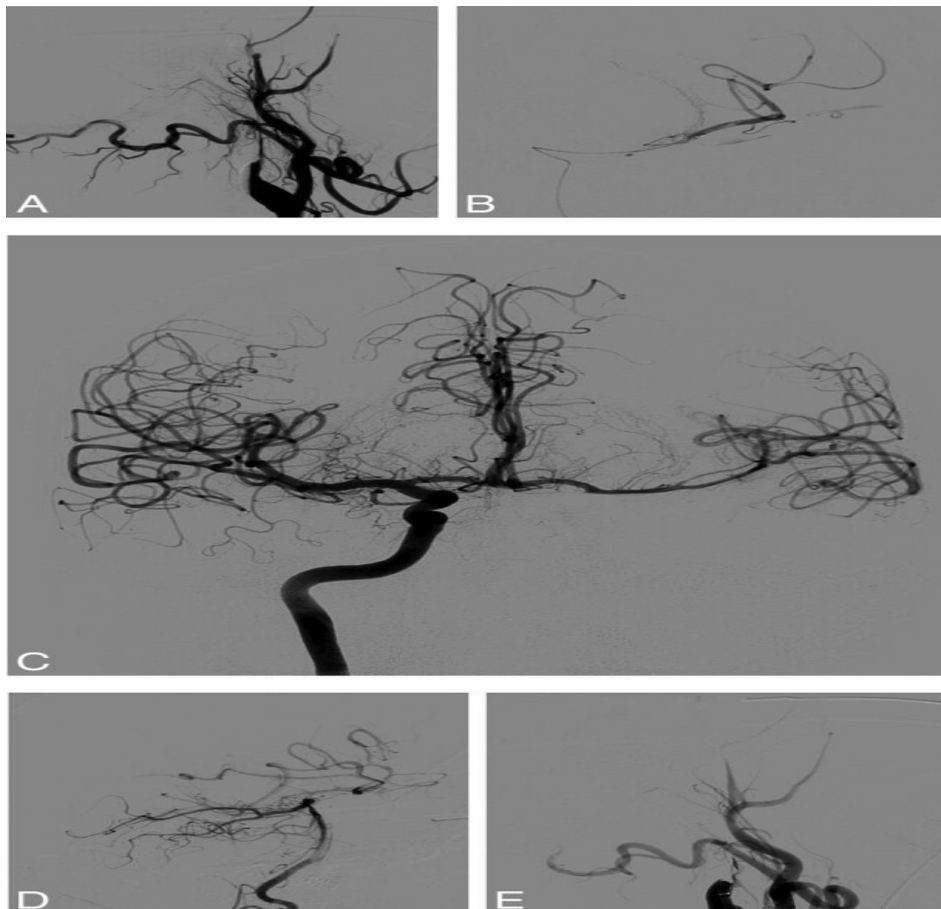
Shows patient presented with severe right hemiplegia and aphasia. Initial MR imaging revealed a DWI-ASPECTS = 6 after 4.5 hours since symptom onset, associated with left tandem ICA and middle cerebral artery occlusions. The initial angiogram (A) demonstrates left internal carotid occlusion related to cervical dissection. the microcatheter is navigated through the dissected ICA to the intracranial occlusion (B). Thrombectomy performed after contralateral femoral puncture and right ICA run shows a functional circle of Willis and no residual left M1 occlusion (C). The posterior communicating artery is also permeable as seen on the left vertebral artery run (D). Consequently, artery was left in its initial condition (E) [23].
